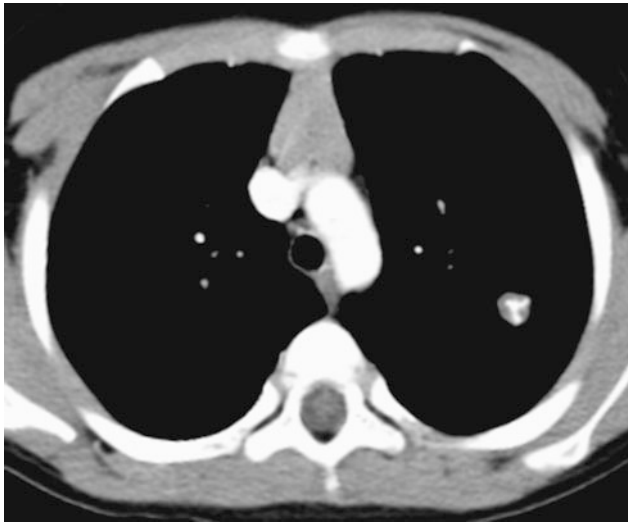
Post-transplantation lymphoproliferative disorder (PTLD). Axial chest CT image from a 15-year-old post lung transplantation demonstrates lobular subsegmental masses of the lower lobes. Biopsy revealed monomorphic PTLD, diffuse large B-cell lymphoma type
